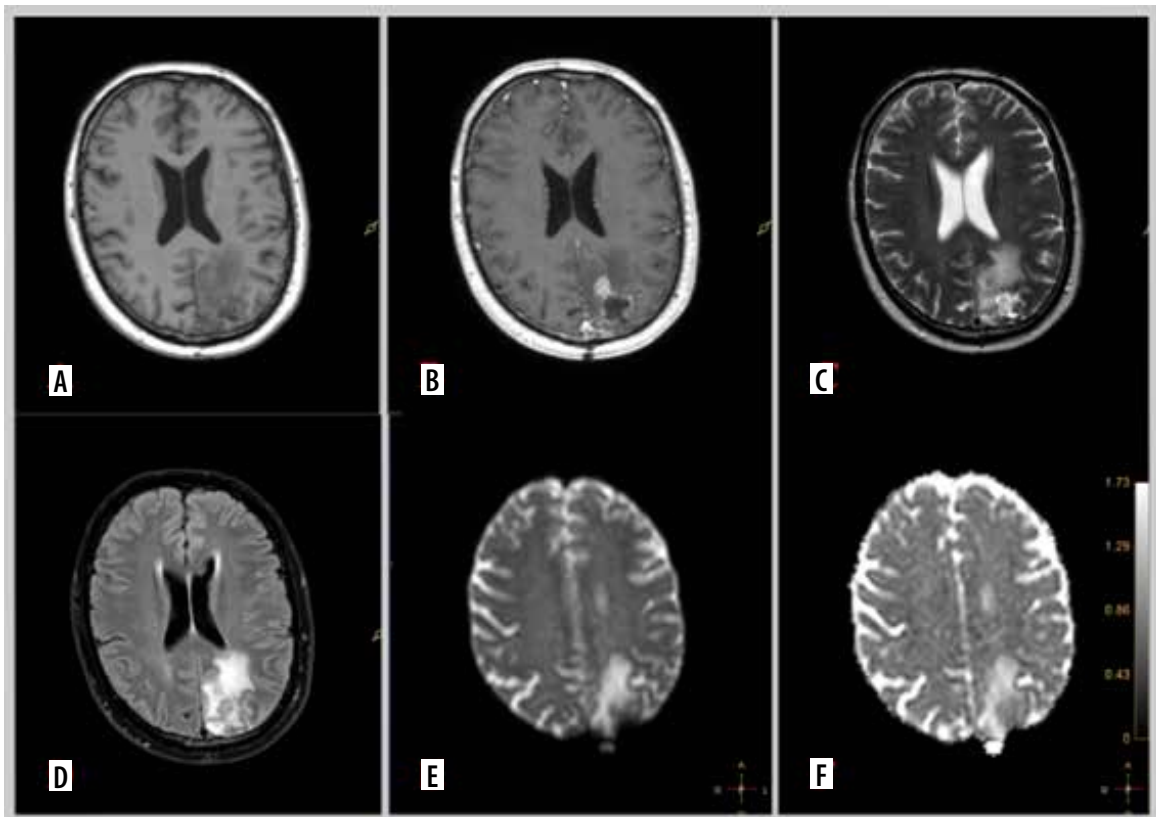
Representative magnetic resonance images of examined patient. A 67-year-old man with glioblastoma G4. Molecular characteristics: *IDH1*-wild-type, present *TERT* promoter pathogenic variant, *CDKN2A* homozygous deletion, *EGFR* amplification, *MGMT* promoter unmethylated. A) Pre-contrast T1. B) Contrast enhanced tumour on T1 post gadolinium. C) T2-weighted scan. D) Fluid-attenuated inversion recovery (FLAIR). E) Diffusion-weighted imaging (DWI). F) Apparent diffusion coefficient (ADC) map
